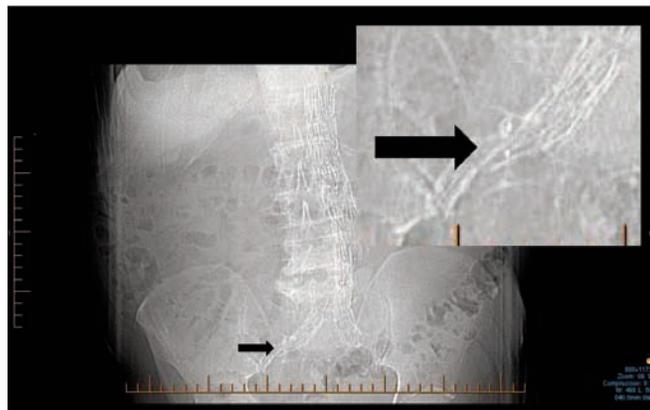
Typical computed tomography scan showing positioning of the Amplatzer vascular plug in the right internal iliac artery.
